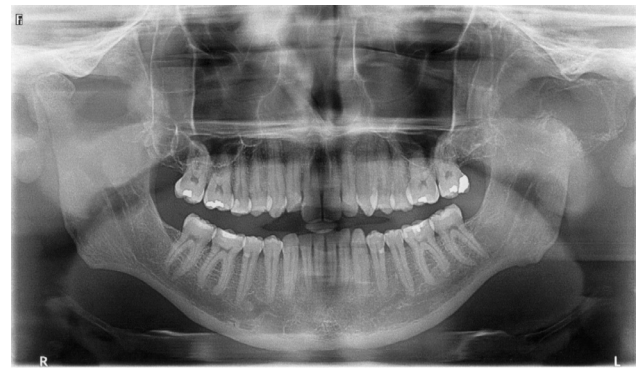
Panoramic radiograph displaying a thinly corticated radiolucent lesion of the left mandibular condyle.
